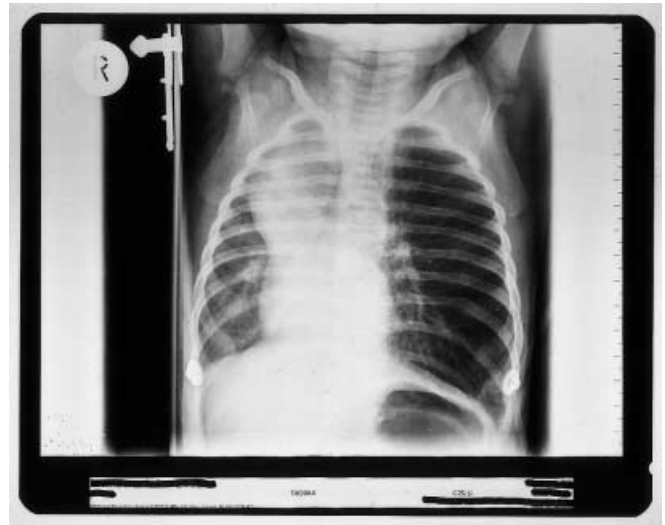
Chest X-ray showing a mediastinal shift to the right side and decreased density of the left lung side
